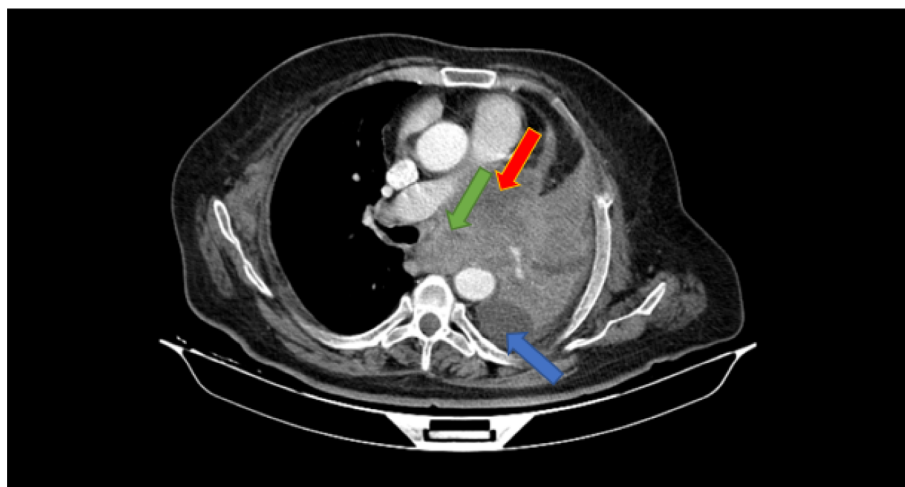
Lung computed tomography scan axial with contrast shows a large necrotic mass (red arrow) in the left hilum with obliteration of the left main bronchus (green arrow), causing complete left lung collapse. The mass invaded the mediastinum and compressed the oesophagus. Moderate pleural effusion (blue arrow) is seen in the left hemithorax
